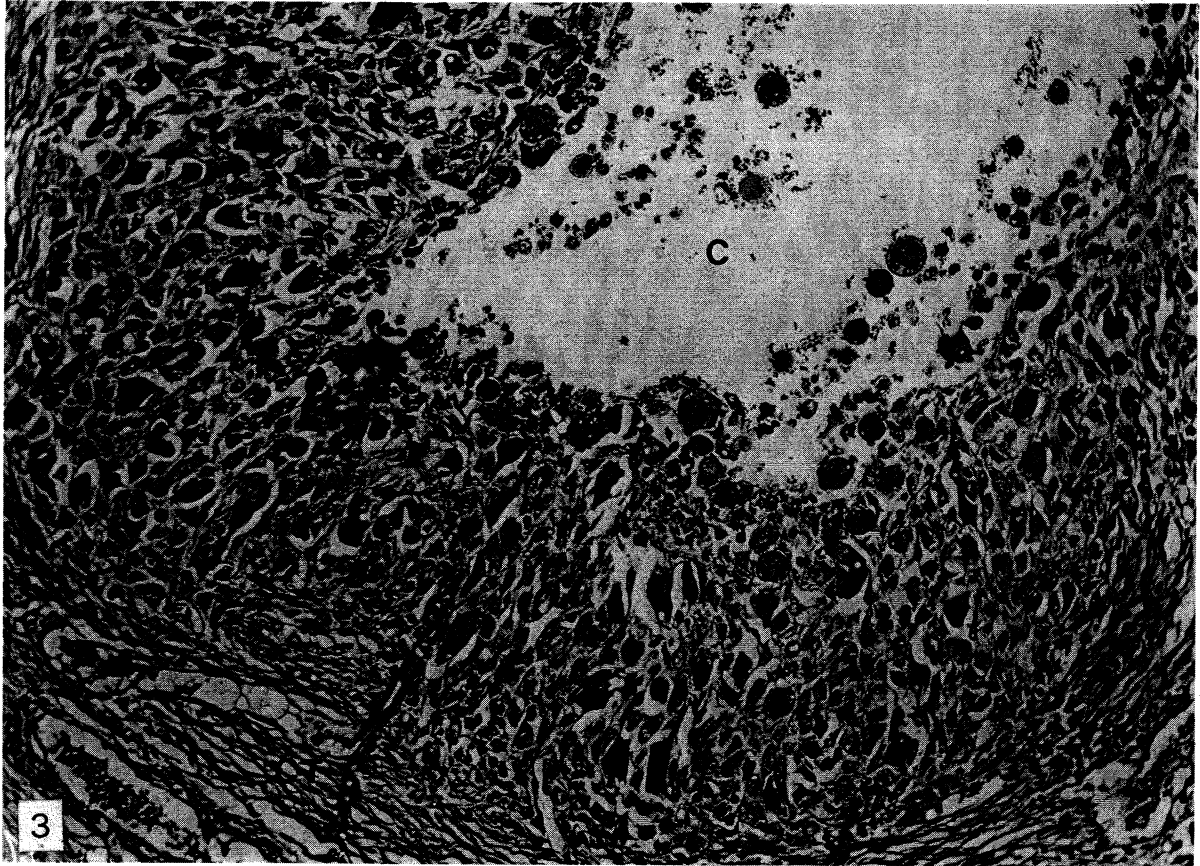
Implantation site tumor; anicnic film; 54 weeks. Focus of pleomorphic tumor cells. Center (C) of pocket which contained implanted plastic is still intact, as is surrounding connective tissue (CT). Masson's trichrome.  $\times 160$
